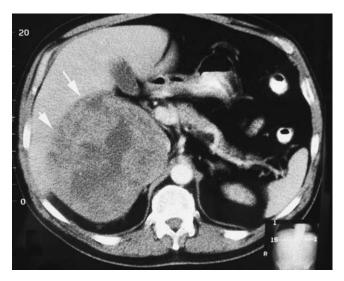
A 60-year-old man had recent onset of severe right upper quadrant pain. A computed tomographic scan shows a 10 cm \times 9 cm \times 8 cm heterogeneous right adrenal tumor (*white arrows*). Biochemical workup showed mild hypercortisolism. He underwent open resection of the right adrenal tumor, with intraoperative findings of invasion into the liver and regional lymphadenopathy.
